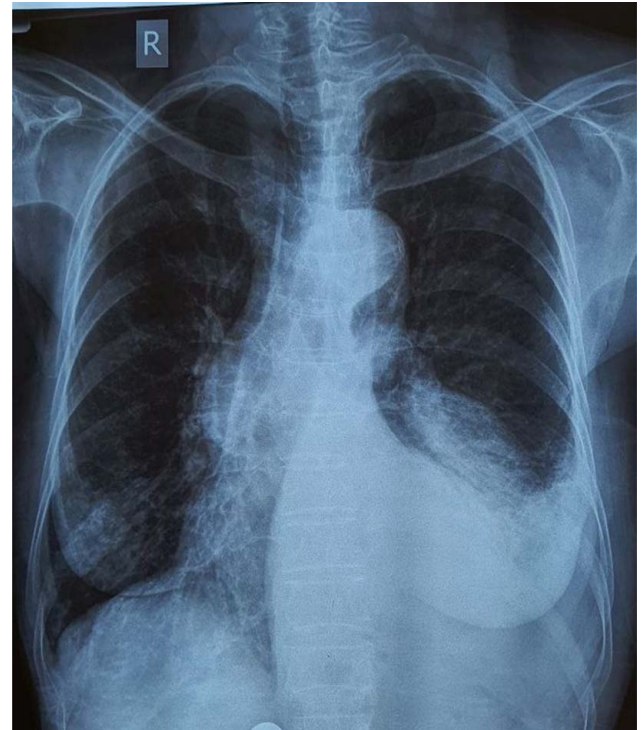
Chest X-ray posteroanterior view showing increased radio-opacity over left lower lung field with obliterated left costo-phrenic angle—likely left-sided pleural effusion.
